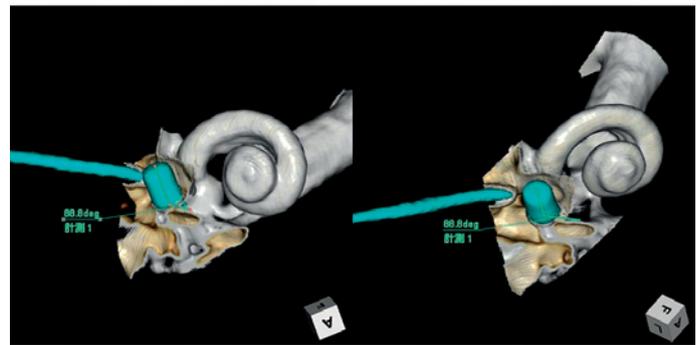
3D-CT images obtained from case N.M.
